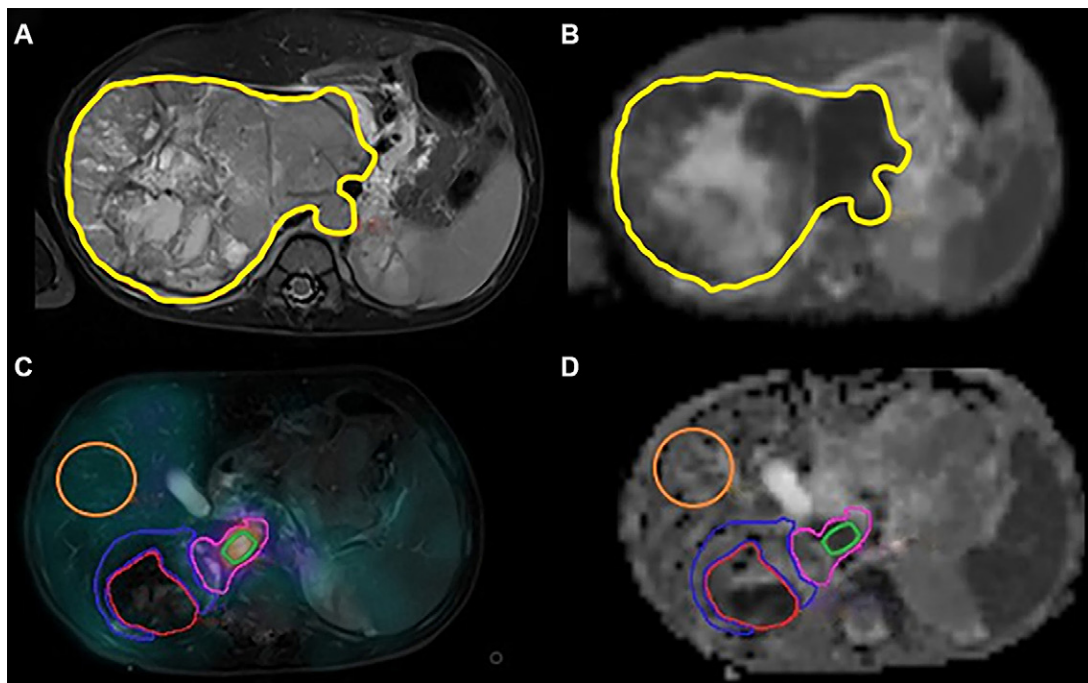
Images in a 20-month-old male patient with high-risk neuroblastoma before and after chemotherapy. (A, B) Axial T2-weighted image and apparent diffusion coefficient map of the primary tumor (outlined in yellow) before chemotherapy, respectively. (C, D) Axial T2-weighted image and axial apparent diffusion coefficient map registered with SPECT iodine 123 metaiodobenzylguanidine (^{123}I -mIBG) after chemotherapy, respectively. The orange liver region of interest was used for normalization, while different regions of interest within the tumor indicate varying levels of ^{123}I -mIBG uptake. The green, pink, blue, and red regions of interest represent high uptake, moderate uptake, low uptake, and no uptake, respectively. (Adapted, under a CC BY 4.0 license, from reference 35.)
